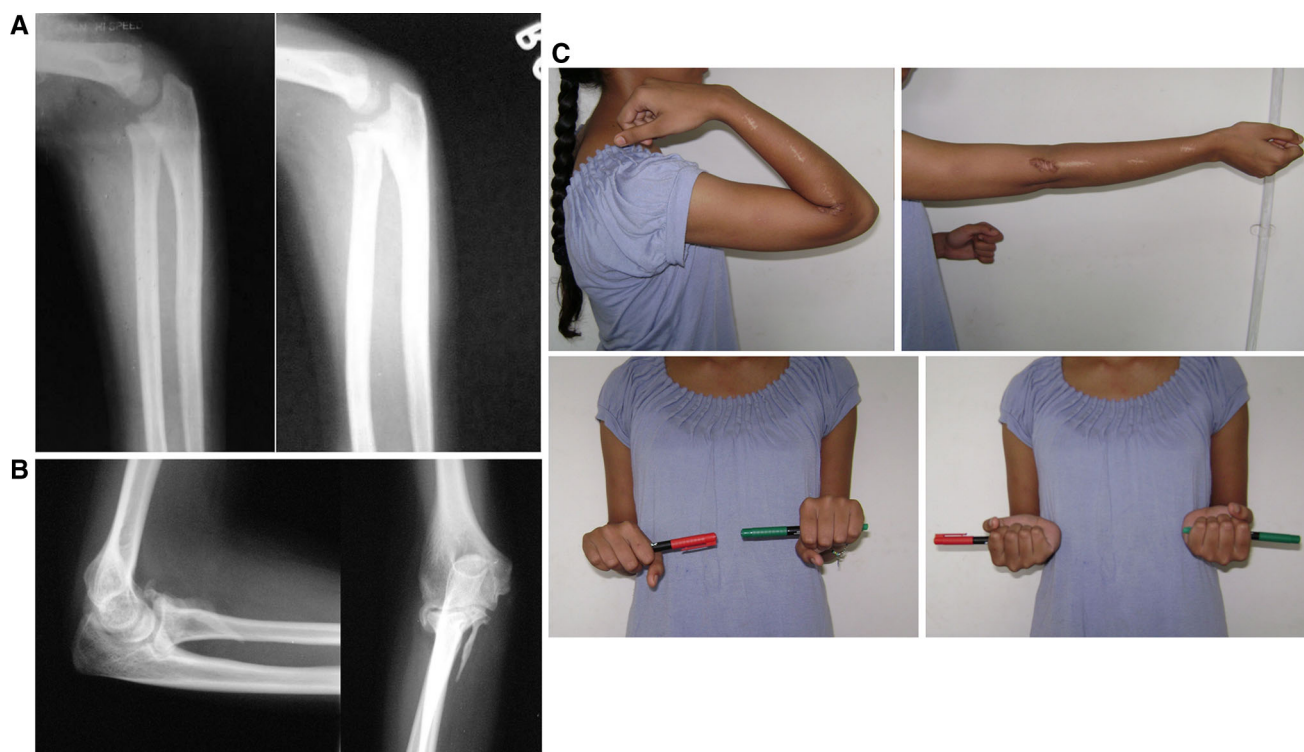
a AP and lateral radiographs of patient with type IV A fracture neck radius at final follow-up. b AP and lateral radiographs of patient with type IV B fracture neck radius, requiring open reduction at final
